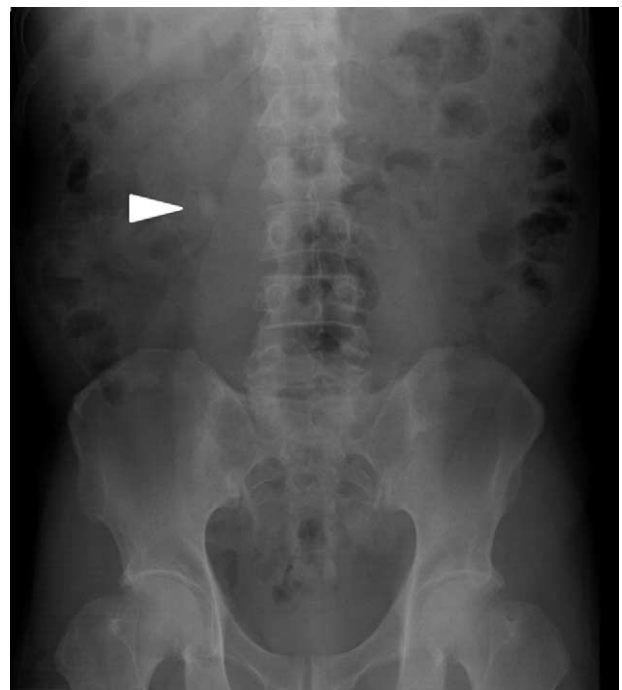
Abdominal radiograph on initial presentation. An abdominal radiograph of the patient on initial presentation showing a radio-opaque calculus with a longitudinal diameter larger than 10 mm in the upper portion of the right ureter (arrow head).
